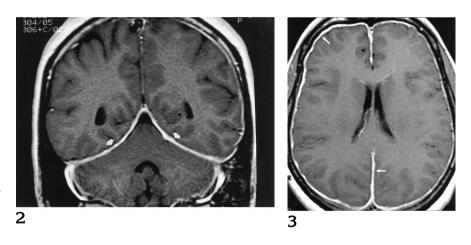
Patient 1: 41-year-old man with severe daily headaches for 1 year. Contrast-enhanced T1-weighted coronal MR image (500/11/1) shows dural enhancement. The headaches significantly improved within 1 day of starting high-dose oral corticosteroid therapy.
